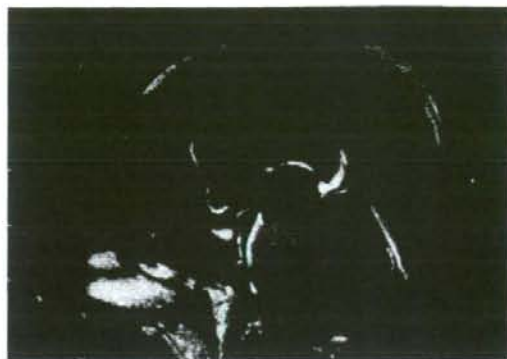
Gadolinium-enhanced MRI after radio-chemotherapy. Complete response was achieved.
